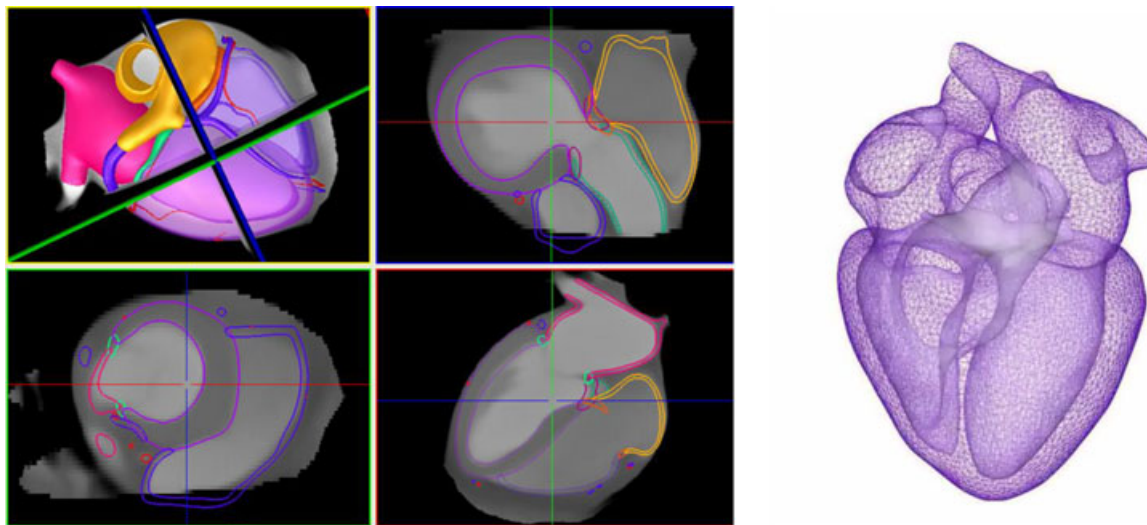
Whole-heart statistical atlas based on a population of about 100 subjects scanned with multidetector computed tomography, each over 15 time points in the cardiac cycle
